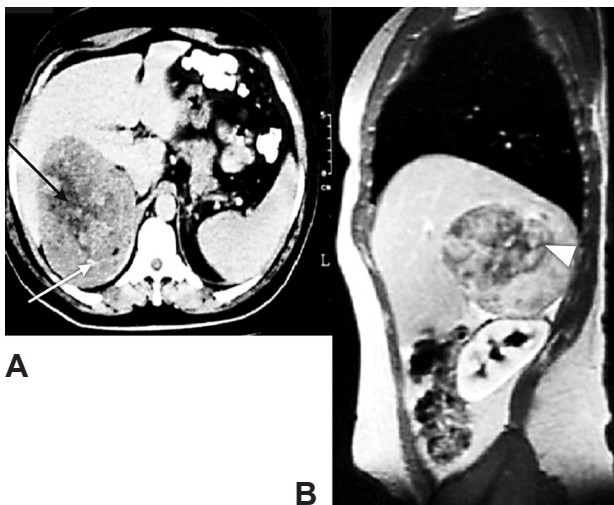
Diagnostic imaging of adrenal mass: A: CT visualization of a large tumor on the right adrenal gland with areas of necrosis causing heterogeneous appearance of the parenchyma (black arrow). It is evident the presence of few small-sized calcifications (white arrow) and the clear margins of the mass from the surrounding structures. B: MRI shows clearly the adrenal origin of the mass (open arrowhead).
